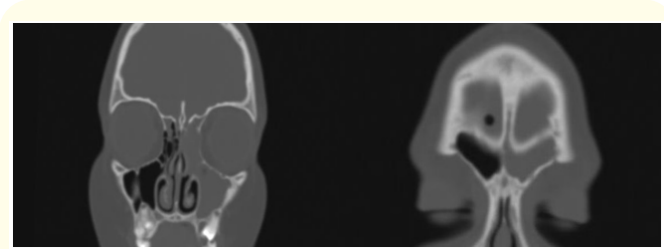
Computed tomography: left maxillo-ethmoidal and frontal sinusitis.
